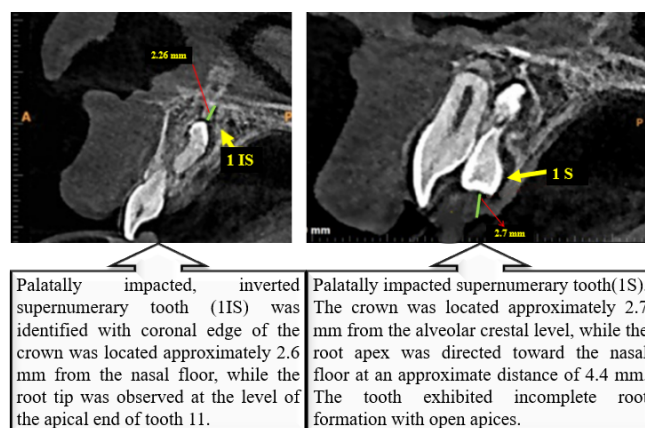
a: CBCT image revealing distance of inverted supernumerary tooth crown from nasal floor. 6b: CBCT image revealing distance of supernumerary tooth crown from alveolar crest level.
